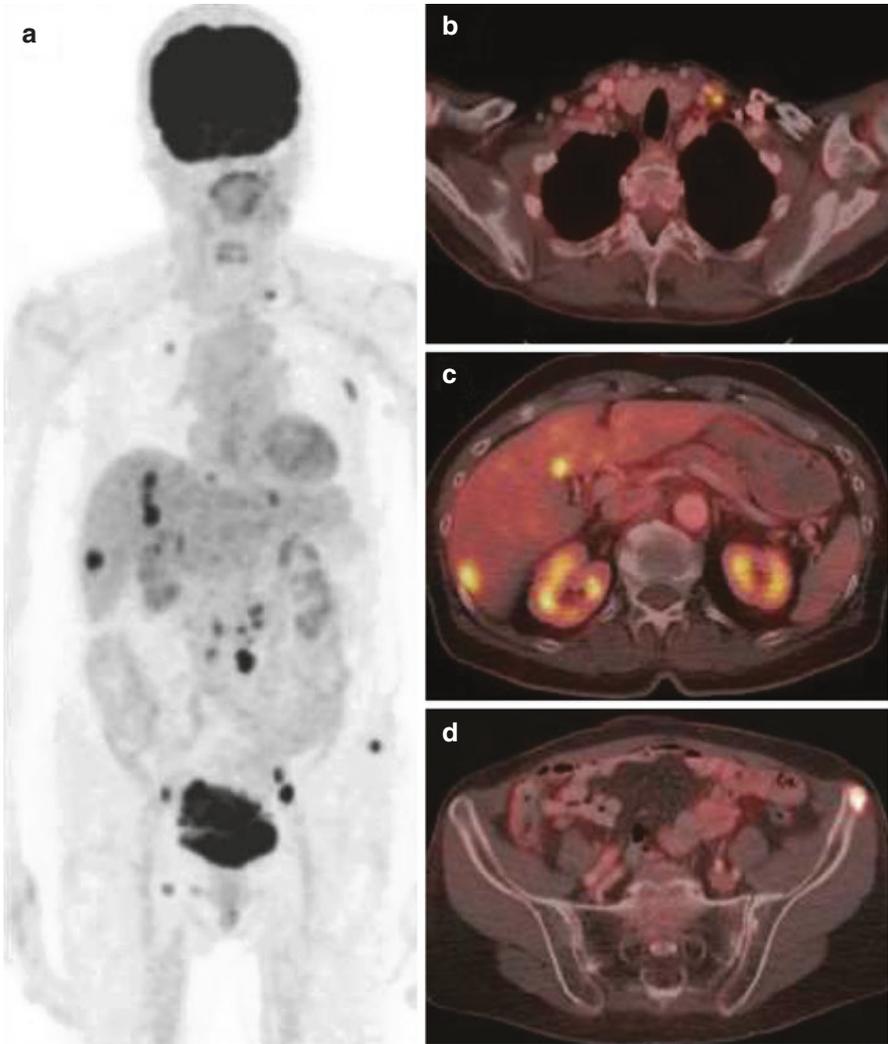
Patient with advanced endometrial cancer: (a) MIP reconstruction of PET shows multifocal hypermetabolic lesions in lymph nodes, liver, and bone. Fused PET/CT images show (b) left supraclavicular lymphadenopathy, (c) liver metastases, and (d) bone metastasis in the left iliac crest
